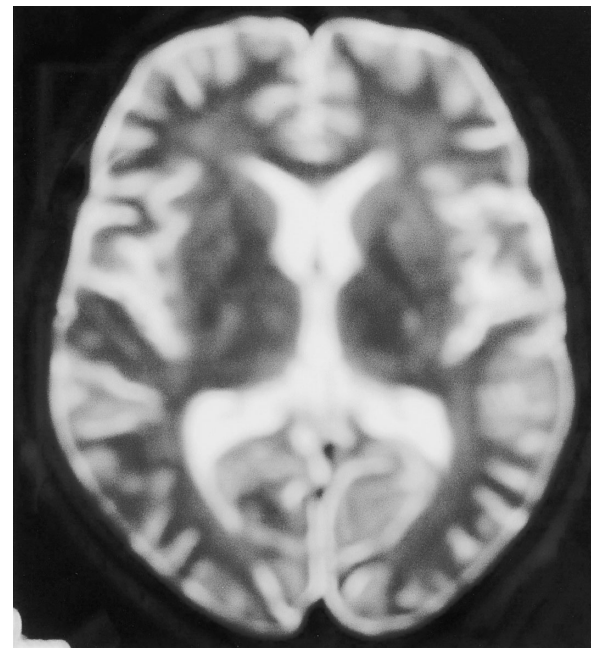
T₂-weighted brain magnetic resonance image showing no signs of infarction or hemorrhage
